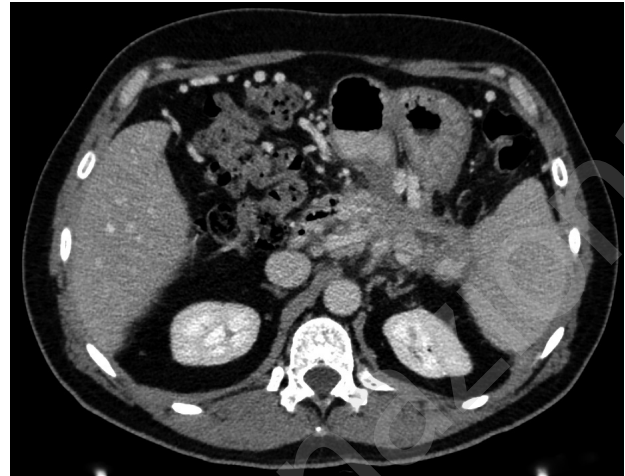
CT scan performed after 6 months and after endoscopic drainage of main pancreatic duct.
